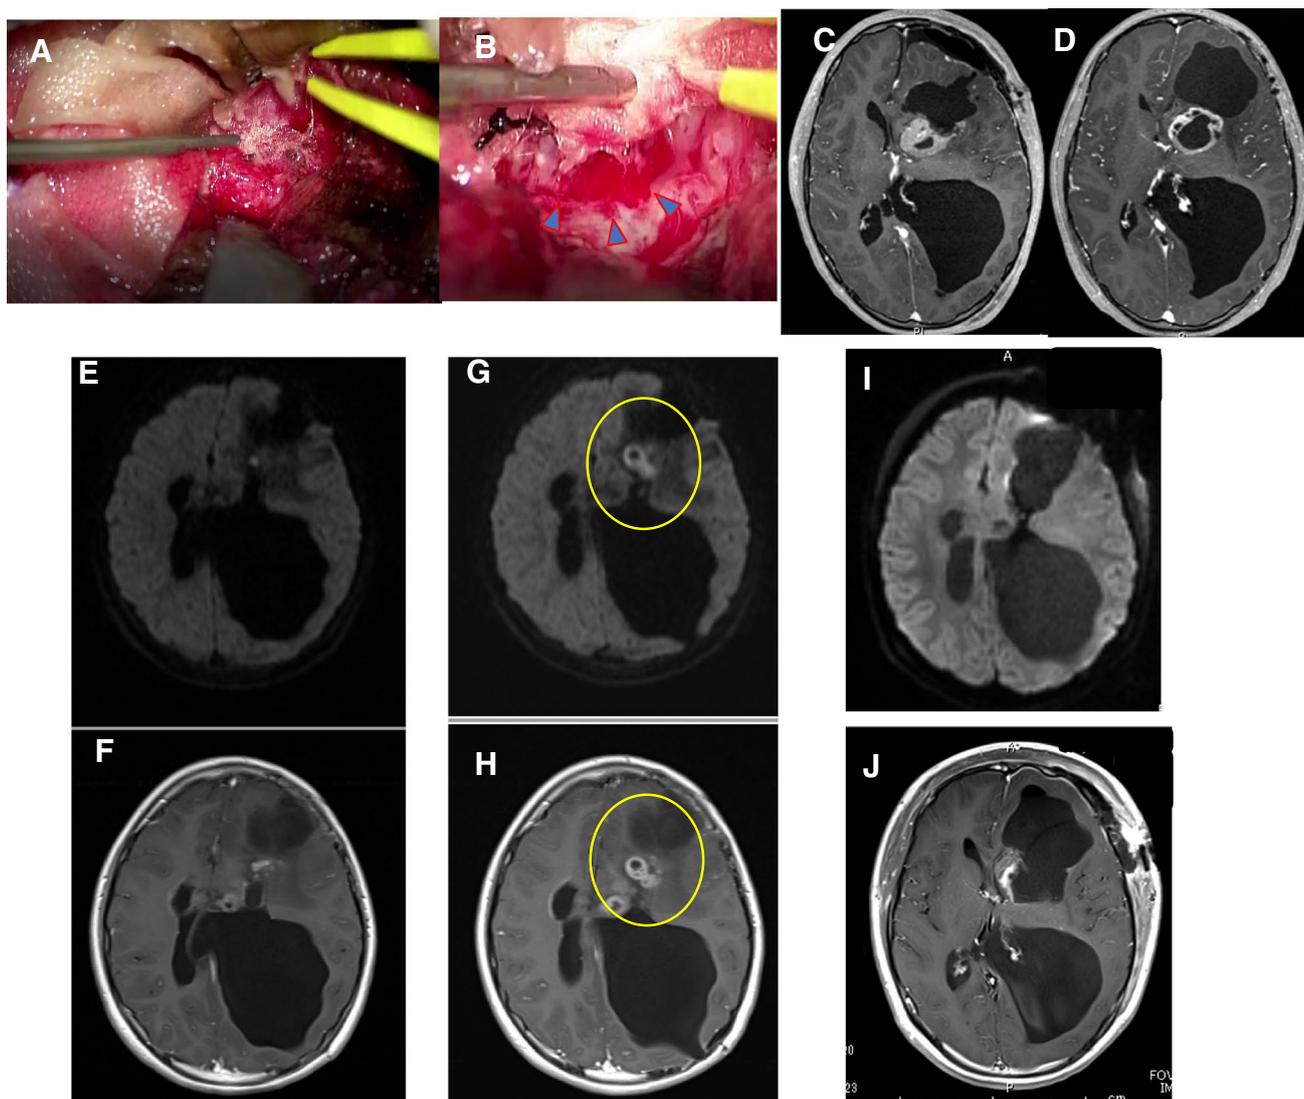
a Intraoperative photograph showed boundary of tumor and skin incision in the left frontal area. Intraoperative image showing a reddish lesion and b that the lesion is well-demarcated. c Postoperative MRI showing residual tumor in the left frontal lobe. d–f Follow-up MRI showing shrinkage of the residual tumor (d, f: Gd-enhanced
